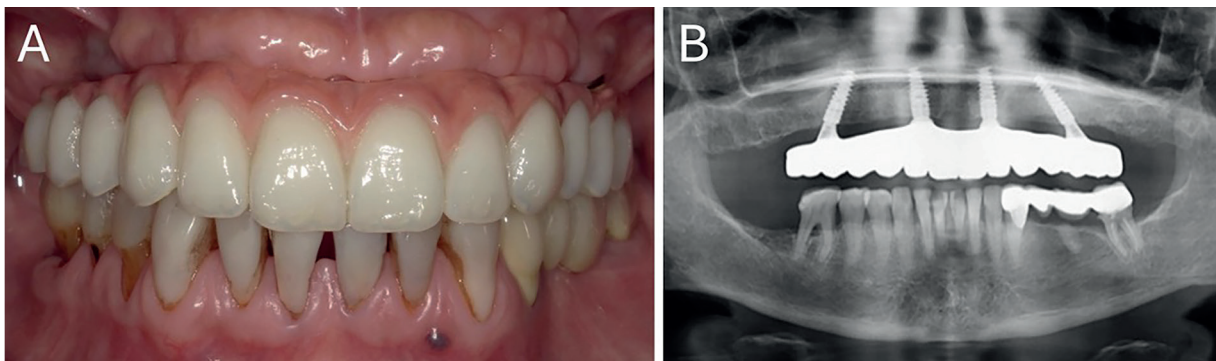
Second case. Rehabilitation of the upper jaw with an implant-supported full-arch fixed dental prosthesis (ISFAFDP). One year follow-up control. (A) Clinical picture of the final monolithic zirconia ISFAFDP in occlusion 1 year after the delivery, frontal view; (B) Panoramic radiograph at 1 year.
